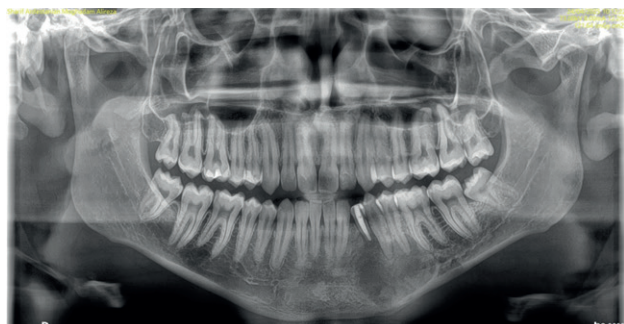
Panoramic radiograph at three months postoperatively, showing signs of remineralization.
